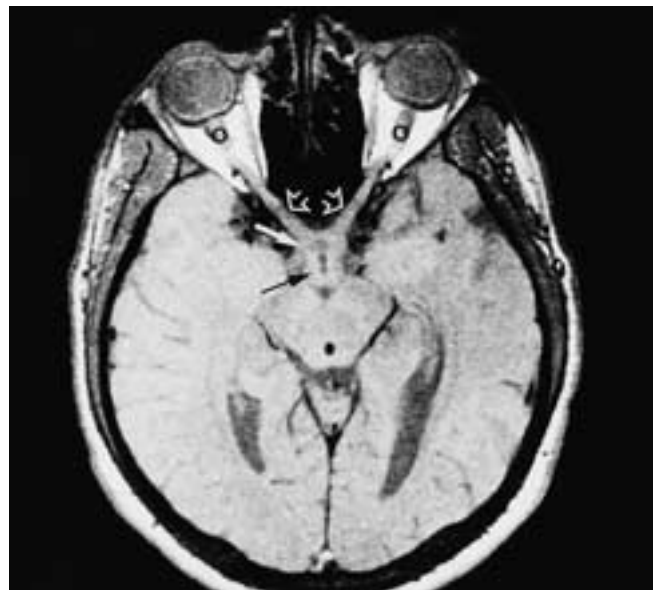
Normal MR imaging anatomy. PW MR image shows the intraorbital segment of the optic nerves (o); intracanalicular segment of the optic nerves (hollow arrows); chiasm (white arrow); and hypothalamus (black arrow).
